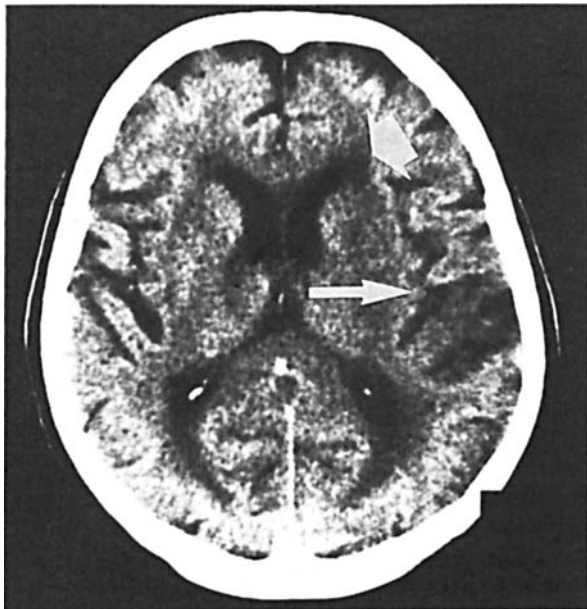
Cranial CT of patient 2: left frontal periventricular hypodensity (broad arrow), and left fronto-temporal cortical atrophy (slim arrow)
